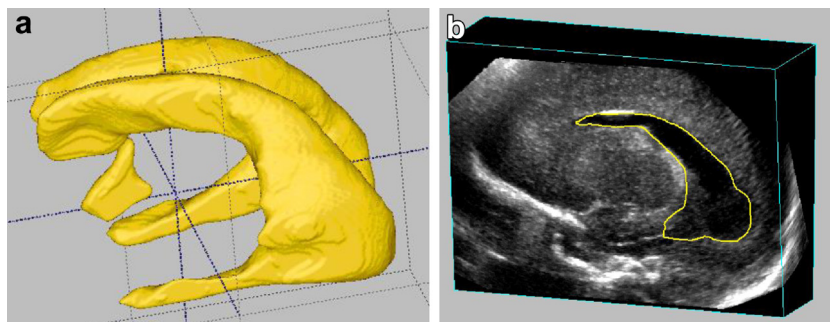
Segmentation of a neonatal ventricular system model from a 3-D ultrasound image. (a) Segmented ventricular system model. (b) Original 3-D US image of ventricular system.
